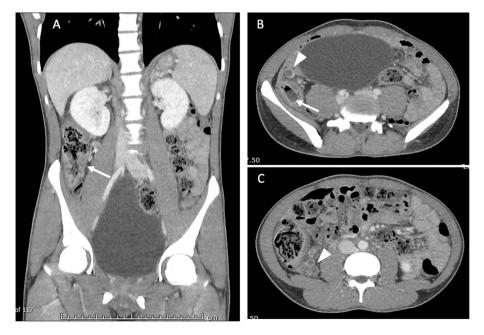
Cecal and colonic tuberculosis. A) Contrast-enhanced CT demonstrates mural thickening and enhancement of the cecum and ascending colon with surrounding inflammatory changes (arrow). B and C) Multiple regional necrotic mesenteric lymph nodes are also evident (arrowhead).
